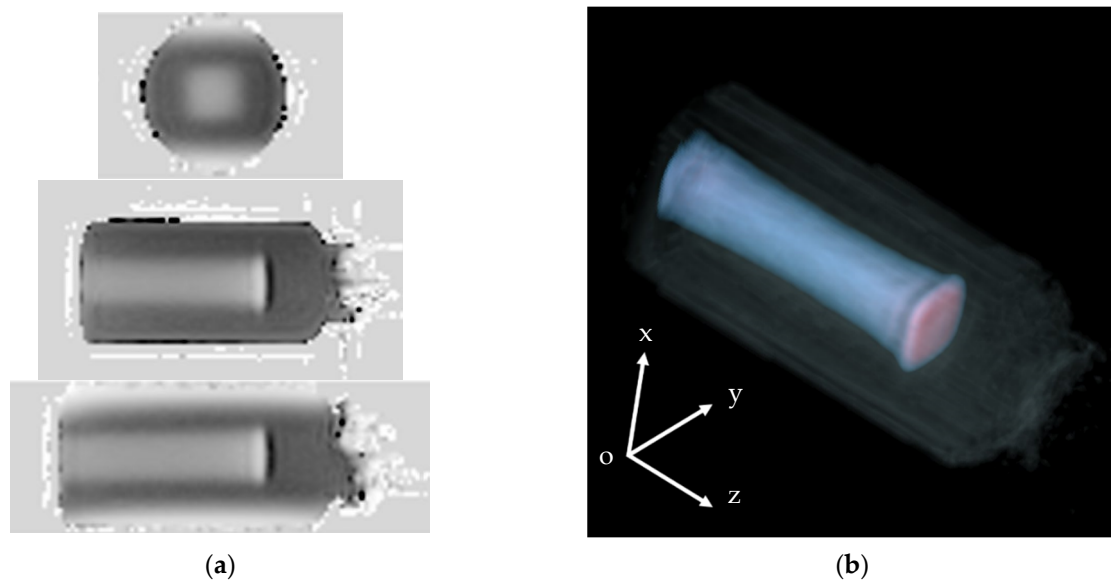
3D image of NC-FG-irradiated 450 Gy ESD obtained from MRI imaging. (a) Using MPR, (b) using volume rendering (VR). The upper, center, and lower panels in (a) are xy, yz, and xz views, respectively.
